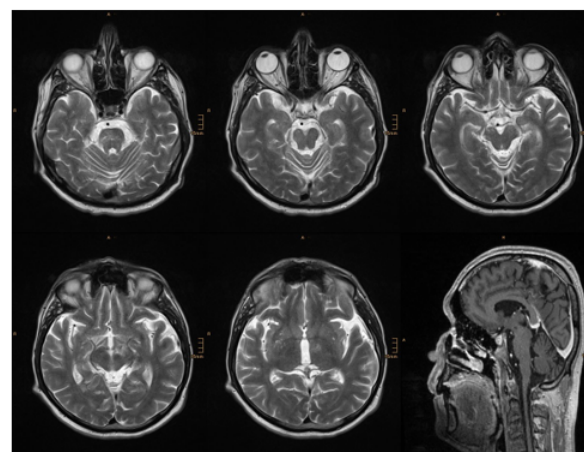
MRI-series of five T2 axial and one T1 sagittal with gadolinium: Significant decline of the pathological findings with recurrent edema, no more mass effect and a further decline in gadolinium enhancement.
